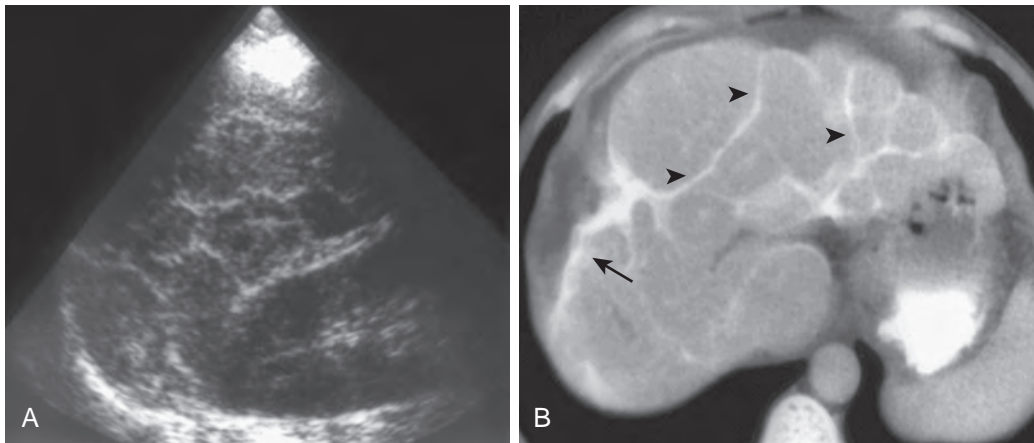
Schistosomiasis on CT and ultrasound. Hepatic *Schistosoma japonicum* infection. A. Sonogram demonstrates thick and densely echogenic bands producing a network pattern. B. Contrast-enhanced CT scan demonstrates capsular calcification (arrow) and gross septations (arrowheads).
